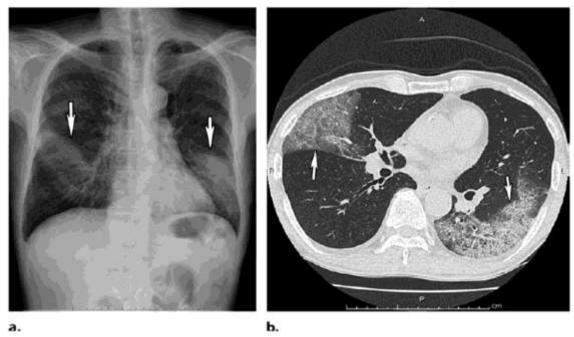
Chlamydial pneumonia in a 28-year-old man. (a) PA chest radiograph shows asymmetric multifocal consolidative opacities (arrows). (b) Axial chest CT image (lung window) at the level of the aortic root shows ground-glass opacities with minimal thickening of the intralobular septa (arrows) in the right middle lobe and left inferior lobe, consistent with multilobar pneumonia.
